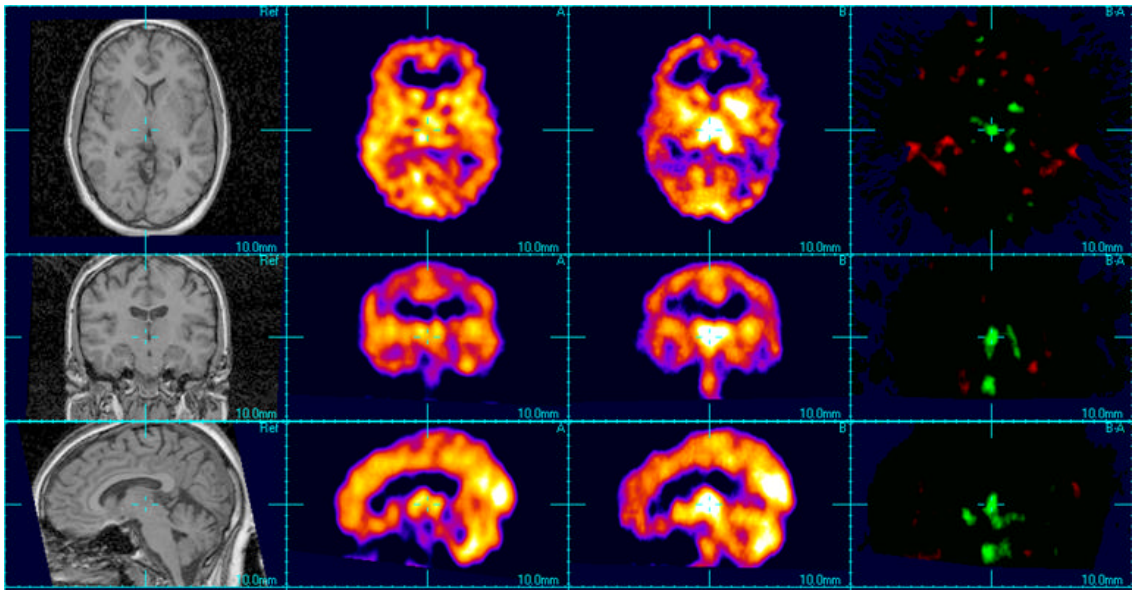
Typical Rview layout with an MRI scan, interictal SPECT scan, ictal SPECT scan, and SPECT difference image (from left to right). The two SPECT scans are normalized to account for global differences in tracer uptake, and the MRI and SPECT scans are aligned in three-dimensional space.
